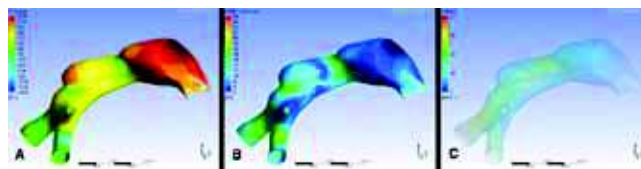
3D-CT analysis displays normal systolic wall pressure (A), low wall shear stress (B) and normal velocity-coded streamlines (C).
